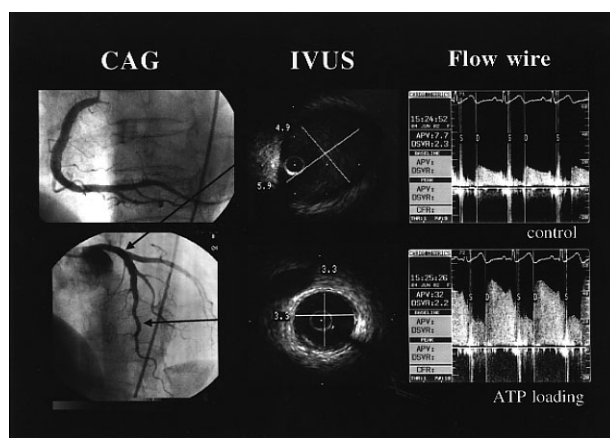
Coronary angiography, Intravascular ultrasound and Doppler blood flow wire. Coronary angiography did not show any stenotic lesions, but diffuse coronary ectasia was noted in three vessels. The maximal diameter of the left anterior descending artery measured by intravascular ultrasound was 5.9 mm. The average peak velocity measured by Doppler blood flow guide wire was 7.7 cm per second, but it improved to 32 cm per second after administration of adenosine triphosphate disodium.
